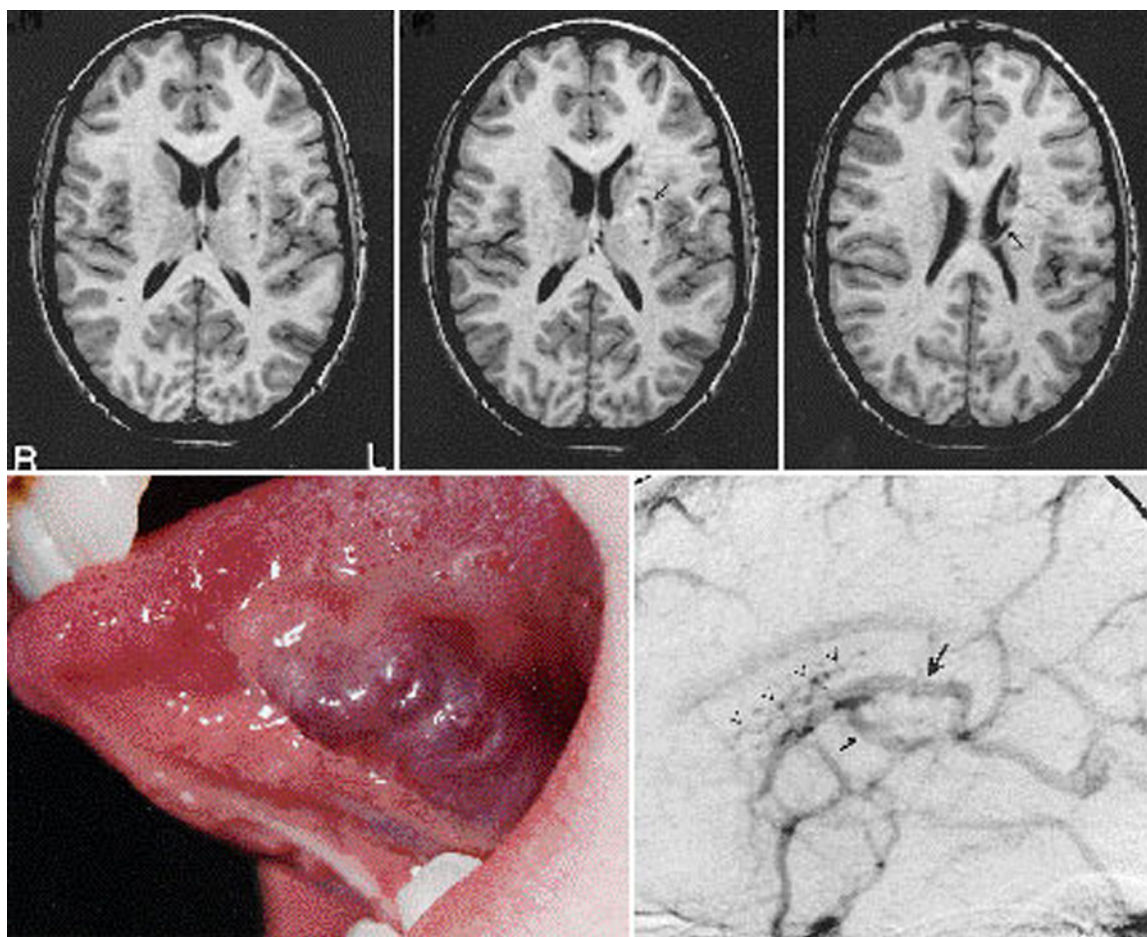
Case 2. *Upper:* Magnetic resonance (MR) images showing punctate, filiform, and serpentine lesions in the region of the left (L) basal ganglia associated with two large draining veins (*arrows*). *Lower Left:* Photograph demonstrating a large lesion of the tongue diagnosed as a cavernous hemangioma on the basis of inspection and palpation. *Lower Right:* Venous phase of a left internal carotid artery angiogram demonstrating the punctate and filiform lesions seen on MR imaging to be small, Medusa-like venous channels (*arrowheads*) drained by a monstrosly enlarged caudate vein (*large arrow*) and tributaries (*small arrow*).
